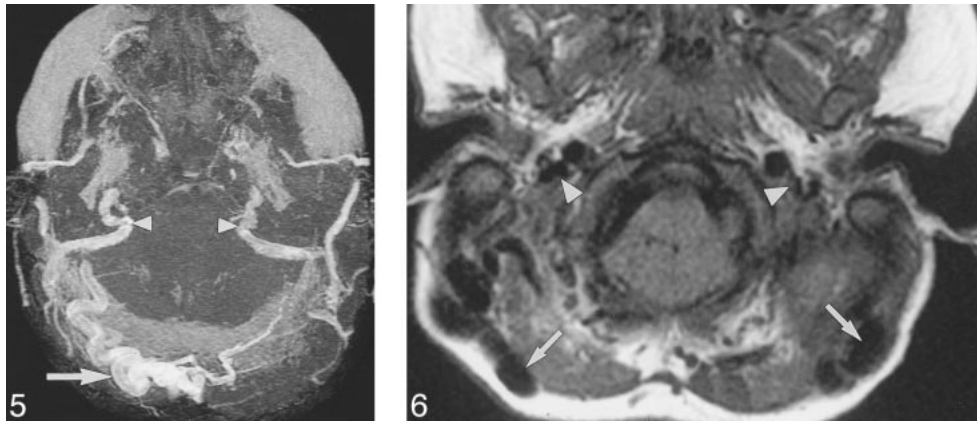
Case 12: A 21-month-old girl with Crouzon syndrome and FGFR2 cys342tyr mutation. Axial collapsed MIP from 3D TOF MRV (53/6.9/1) 20 months after the initial CT shows JFS. There is stenosis of both transverse and sigmoid sinuses and the internal JV (arrowheads). There are large, right, occipitomastoid EV (arrows).
